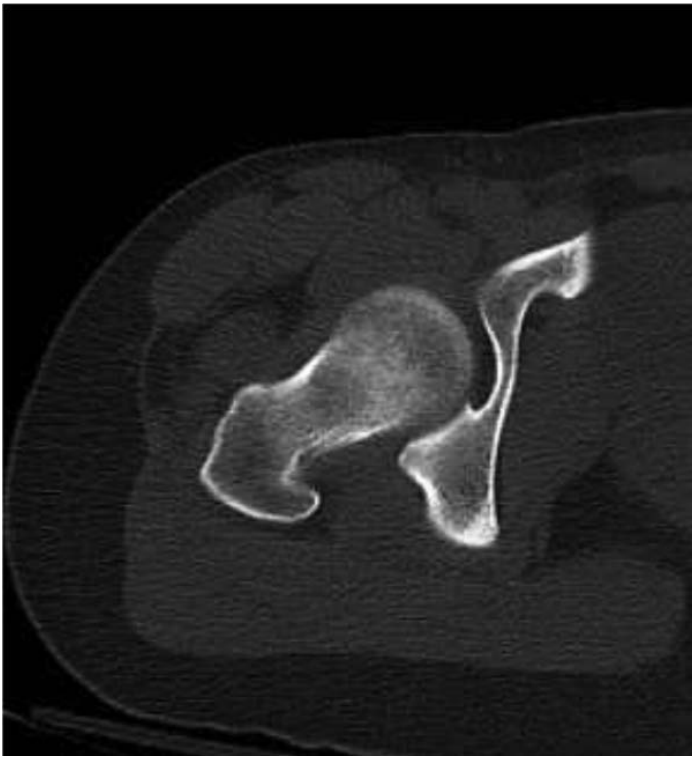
Axial CT cut of reduced hip displaying anteversion.
